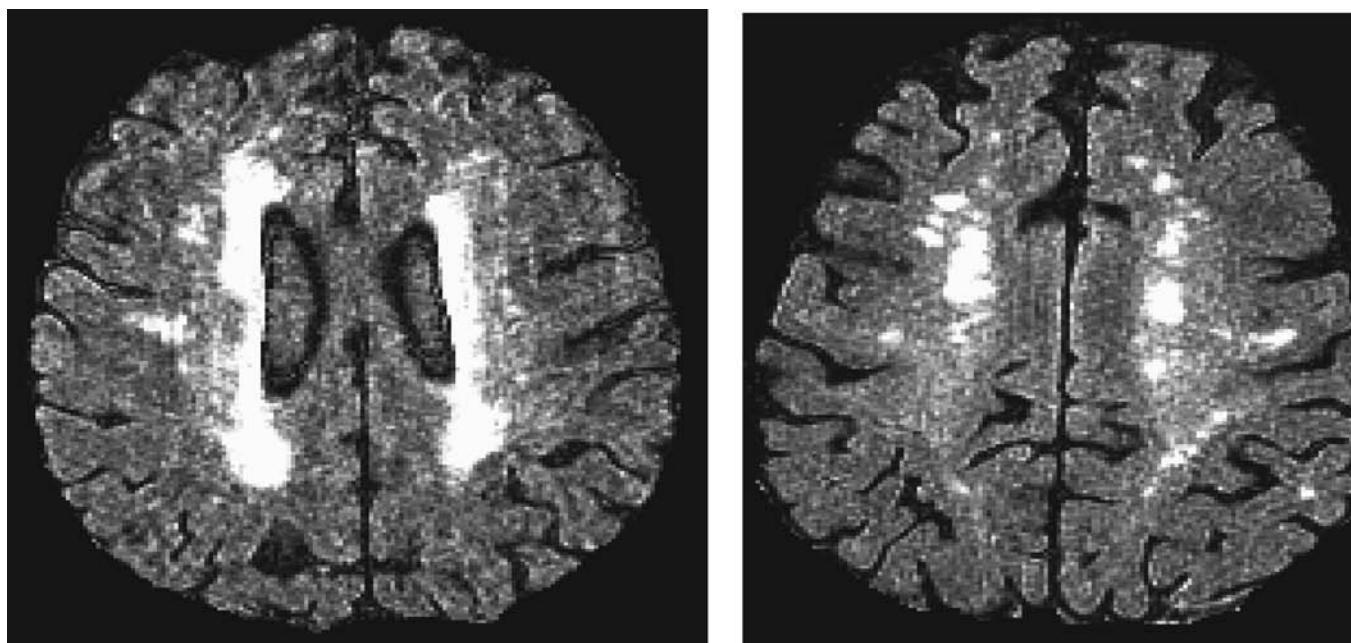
Fluid-attenuated inversion recovery (FLAIR) images of a patient with late-onset major depression. White or bright areas show magnetic resonance imaging (MRI) hyperintensities. The image on the left demonstrates periventricular hyperintensities, with a broad band of increased signal adjacent to the lateral ventricles and invading the deep white matter. The image on the right, from the same patient at a higher level, shows multiple, confluent foci of hyperintensities in the deep white matter (centrum semiovale).
